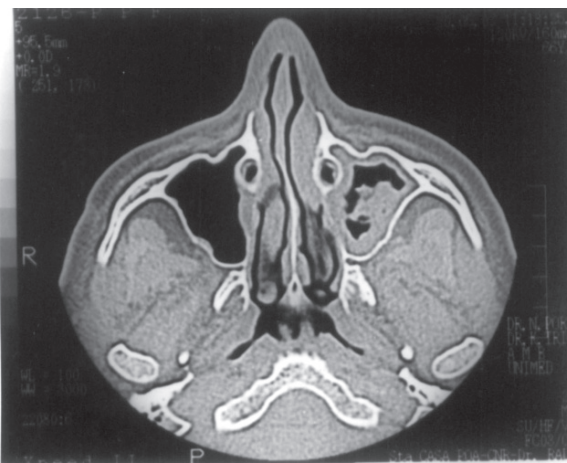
A computed tomographic scan shows partial opacification of the left maxillary sinus along with thickening of the sinus mucosal with irregular soft tissue mass, with anfractuous contours.
